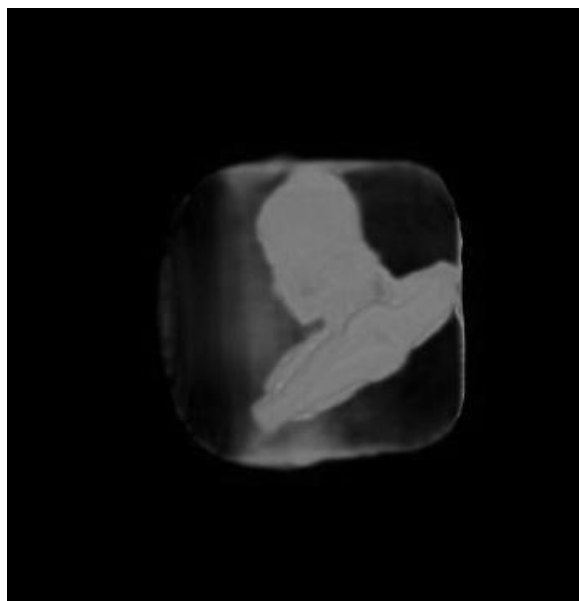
Example of obtained 3D picture from CT program
